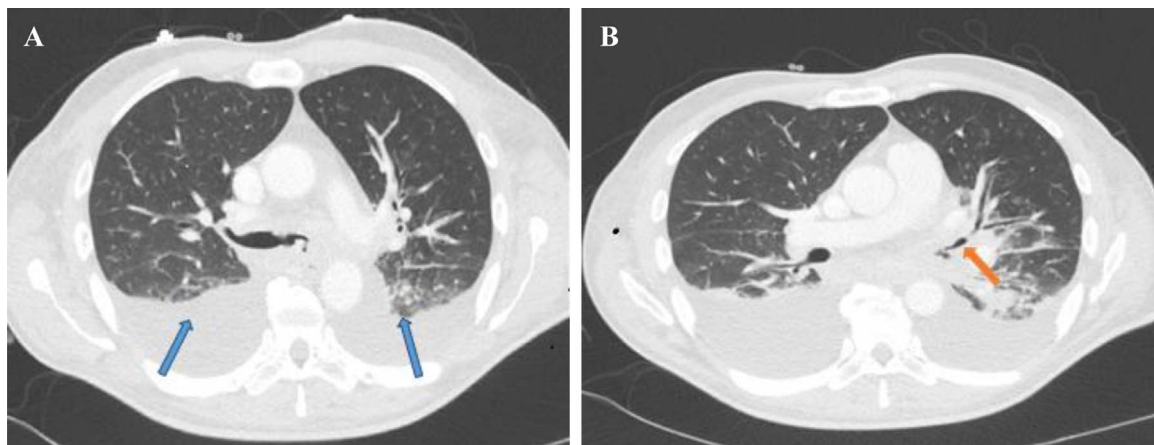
Initial thoracic CT scan, axial section. A: bi-basal condensation (blue arrows). B: infiltration of left main bronchus (orange arrow).
